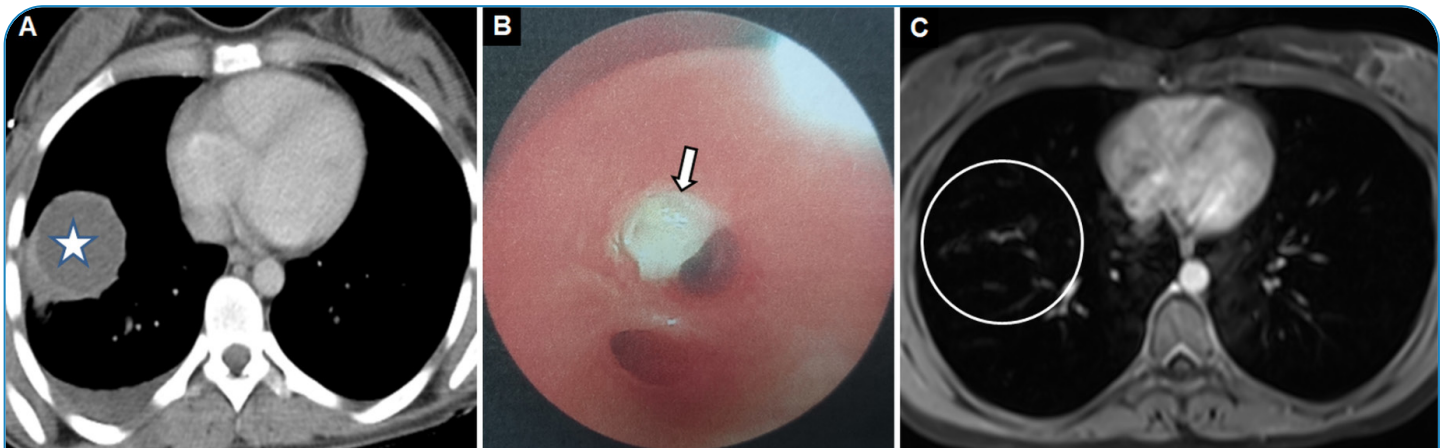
Axial computed tomography scans showing a hydatid cyst of 45-mm diameter with a unilocular water-dense lesion (indicated with star) and pleural effusion (A). Flexible bronchoscopy findings showing a membrane (arrow) originating from the hydatid cyst in the anterior basal segment of the right lower lobe (B). Control axial T2-weighted magnetic resonance image (circle) showing spontaneous healing of the hydatid cyst 3 months later (C).
